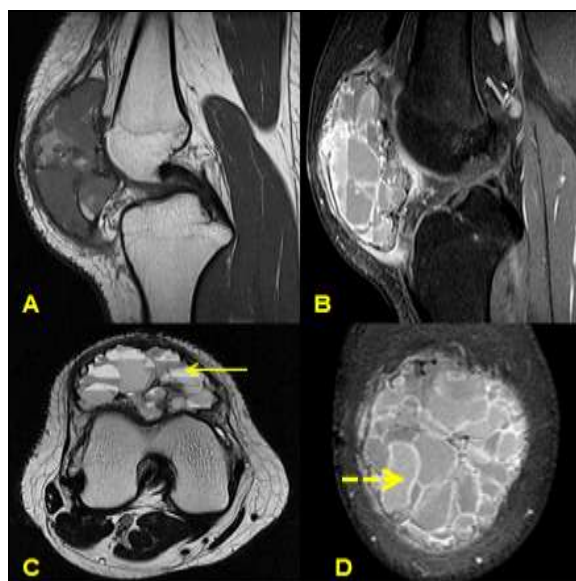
MR images Saggital T1 (Image A) and Axial T2 (Image C) showing iso to hypointense lesion with fluid-fluid levels (arrow). Post contrast Fat saturation (Image B and D) showing multiple internal enhancing septations
